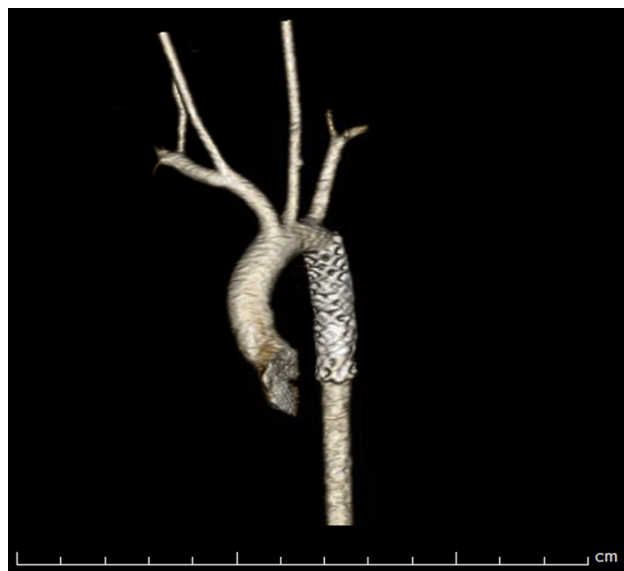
Follow-up CT angiogram reconstruction of the stents confirming absence of endoleak.
